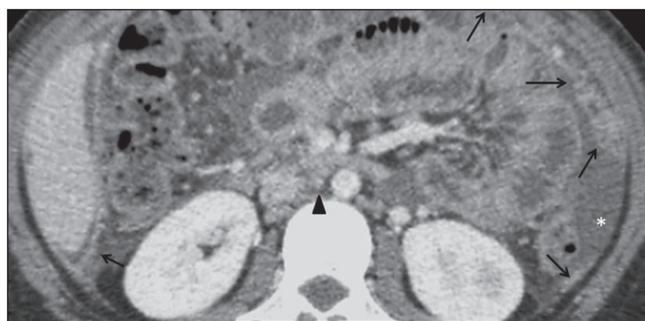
Contrast-enhanced axial CT image of the abdomen. Nodular peritoneal thickening (arrows), ascites (asterisk), and retroperitoneal interaortic adenopathies (arrowhead).
